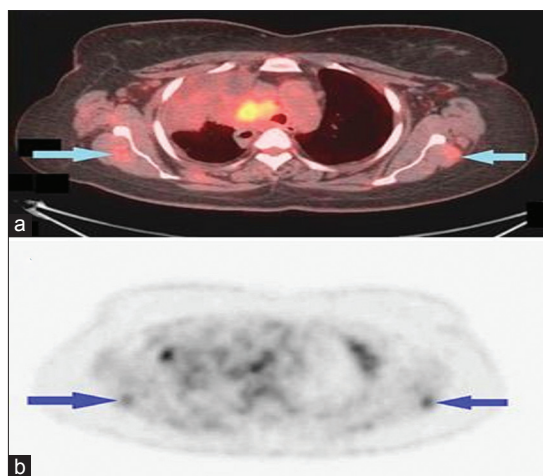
Whole body 18F-fluorodeoxyglucose positron emission/computed tomography scan post 3 cycles of chemotherapy showing new findings of fluorodeoxyglucose avid soft-tissue metastases to bilateral supraspinatus muscles (blue arrow) (a) fused image; (b) maximum intensity projection image
